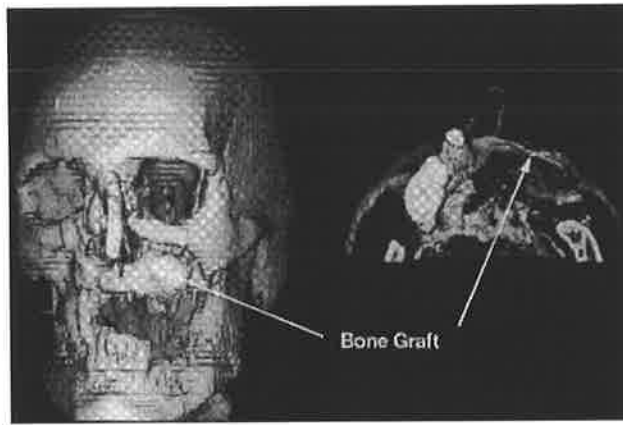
3D CT images of missile victim. The titanium substructure was designed to fit onto the rib graft.
